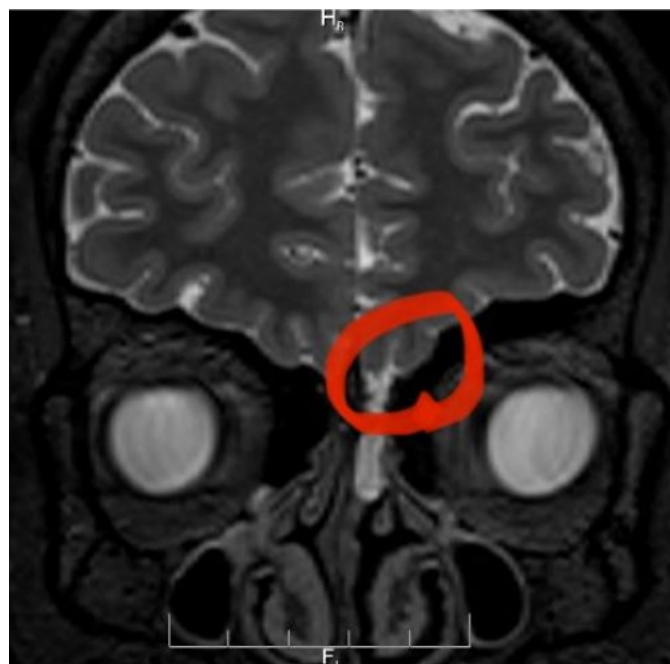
T2-weighted MRI brain showing CSF leak in left cribriform plates, circled in red.
